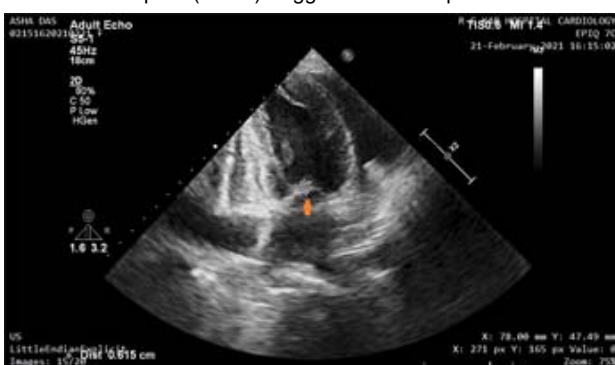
Apical two chamber view showing vegetation at ventricular aspect of anterior mitral leaflet (AML) (Arrow)
